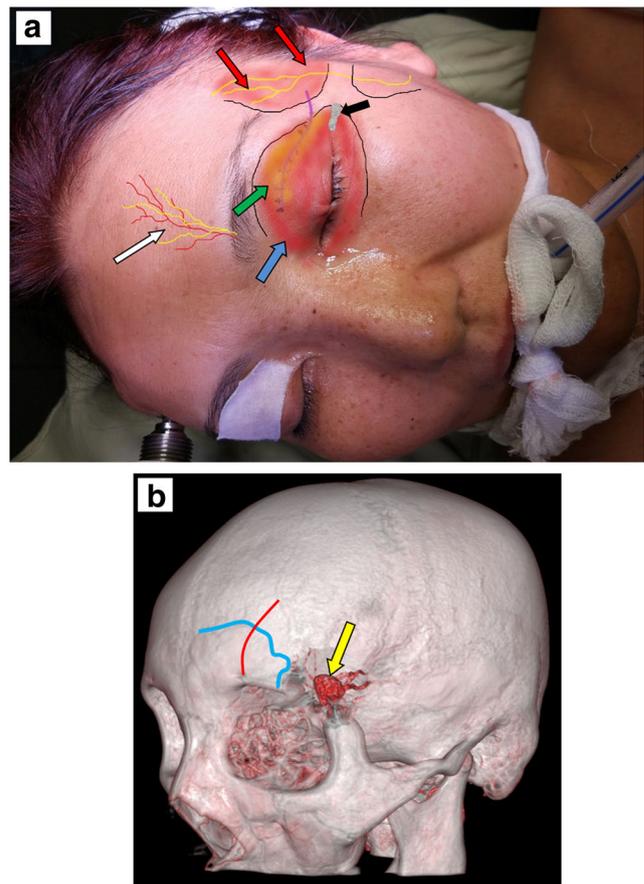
a Relevant surgical anatomy landmarks for transpalpebral approach. Patient's head position. Black lines – bones margins. Arrows: white – supraorbital artery and nerve, blue with red area – musculus orbicularis oculi, green arrow with yellow area – subcutaneous tissue, black – lateral canthal ligament, red – temporalis muscle (red area) and branches of facial nerve, violet line – projection of skin incision. b Preoperative CT angiography for approach planning. Red line – projection of supraorbital artery and nerve, blue line – border of frontal sinus, and yellow arrow – left internal carotid artery aneurysm
